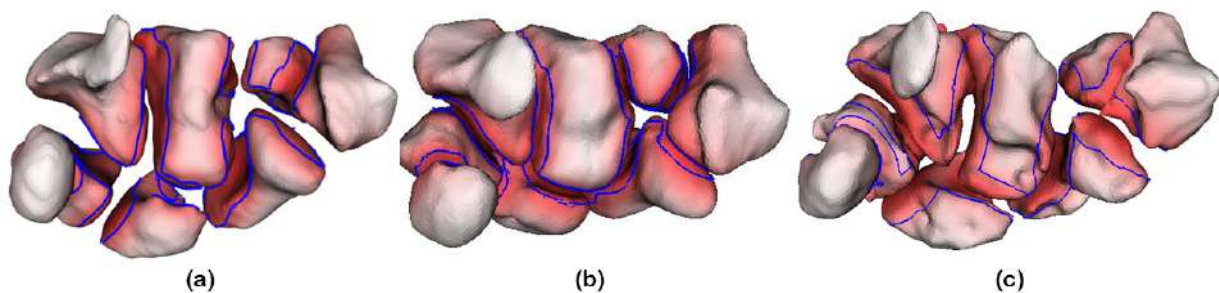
The computation of the Shadow map applied on: (a) models segmented from MRI images; (b) models segmented from CT images; (c) a pathological case affected by Rheumatoid Arthritis stage 3 (pinker areas indicates higher values of the shadow map).
